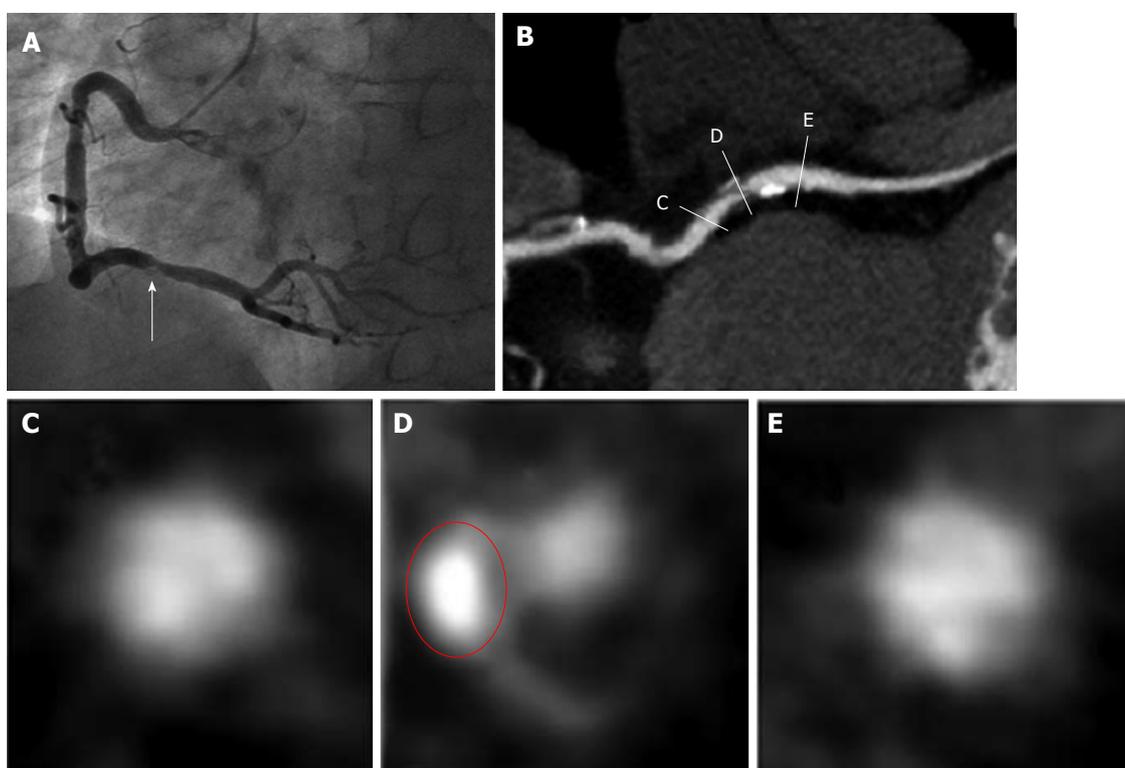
The computed tomography characteristics of a culprit lesion in the 52-year-old male patient with post-percutaneous coronary intervention troponin T elevation $\geq 3 \times$ the upper limit of normal^[31]. Coronary angiogram (A) and multiplanar reconstructed image (B) show severe stenosis in the mid right coronary artery. Cross-sectional images show the proximal reference (C), culprit lesion (D), and distal reference (E). The lesion has positive remodeling (remodeling index 1.28), spotty calcification, and low CT density (16 HU). Red circle indicates area of spotty calcification. CT: computed tomography; HU: Hounsfield units.
